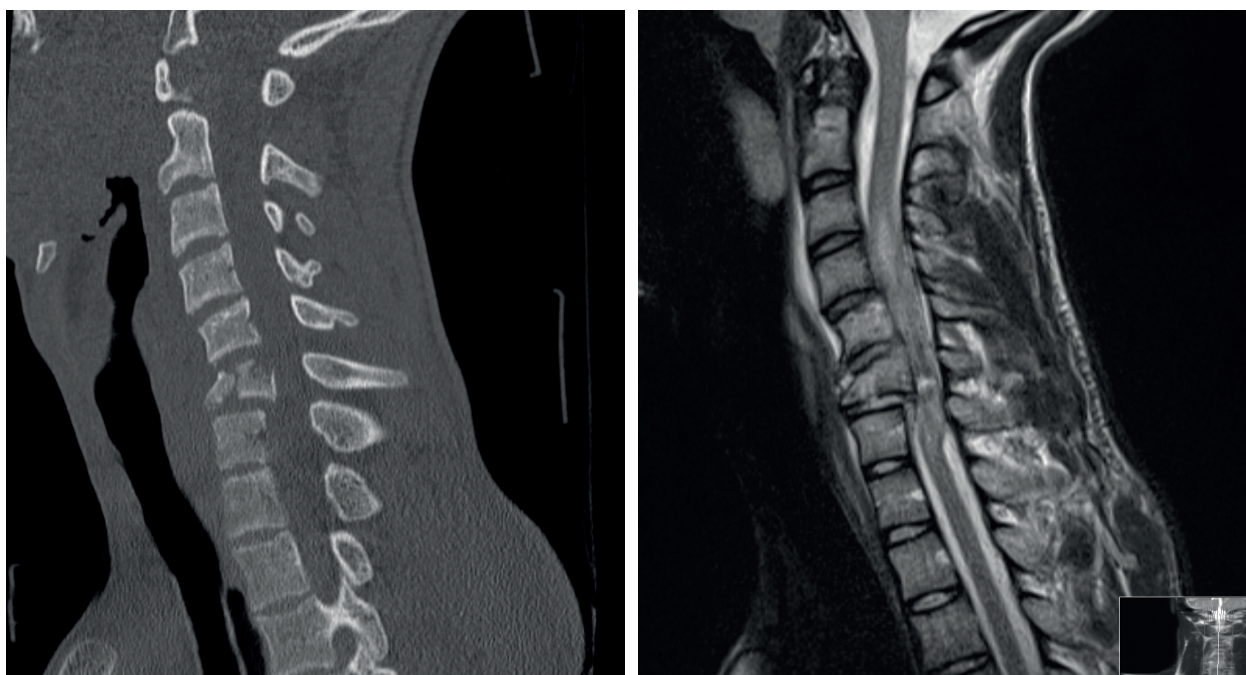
A seventeen year old male who fell 2.5 meters on his head causing axial trauma and overflexion of the cervical spine. Sagittal CT scan (1 hour after injury) and T2-weighted MRI scan (4.5 hours after injury) showing a comminuted flexion tear drop fracture of the sixth cervical vertebral body with a dorsal fragment compressing the spinal cord, causing local bleeding and spinal cord edema from C3 to C7. The patient was completely paralyzed below the sixth neurological cervical segment. The spinal cord was immediately decompressed and stabilized through removal of C4-C7 discs and fractured C5-C6 vertebral bodies with subsequent anterior fusion.
